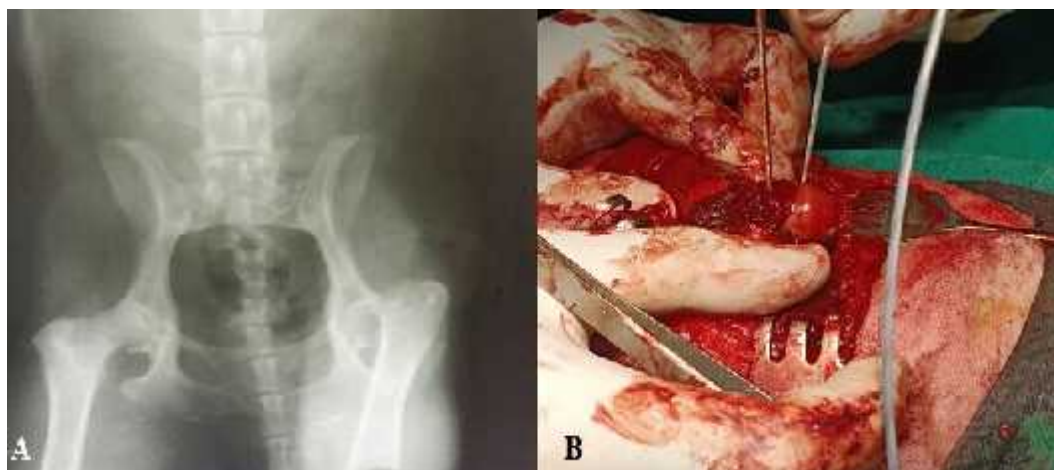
(A) Hip ventro-dorsal radiograph revealed cranio-dorsal luxation of the left coxo-femoral joint (B) The femoral head and neck osteotomy was performed using a giggle wire
